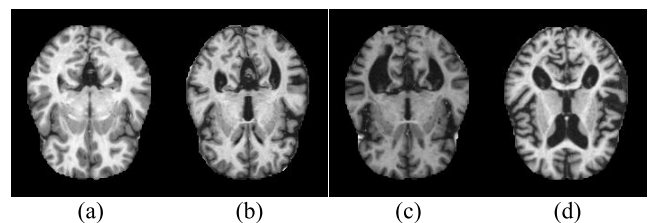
A class example of an MRI datasets for diagnosing Alzheimer's disease. (a) Non-Demented, (b) Very Mild Demented, (c) Mild Demented, (d) Moderate Demented.
